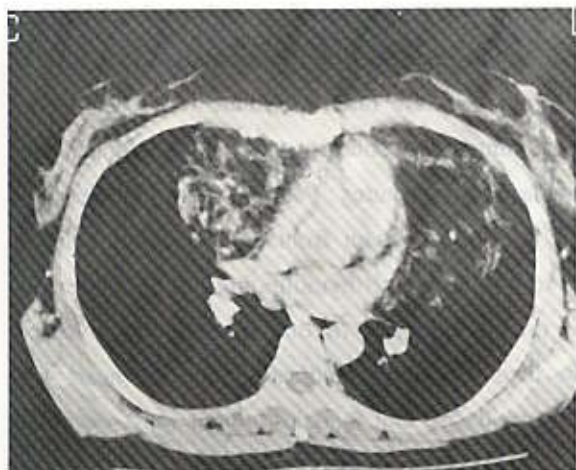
CT-scan of the chest (mediastinal window) demonstrates fat intermixed with soft tissue attenuation.
